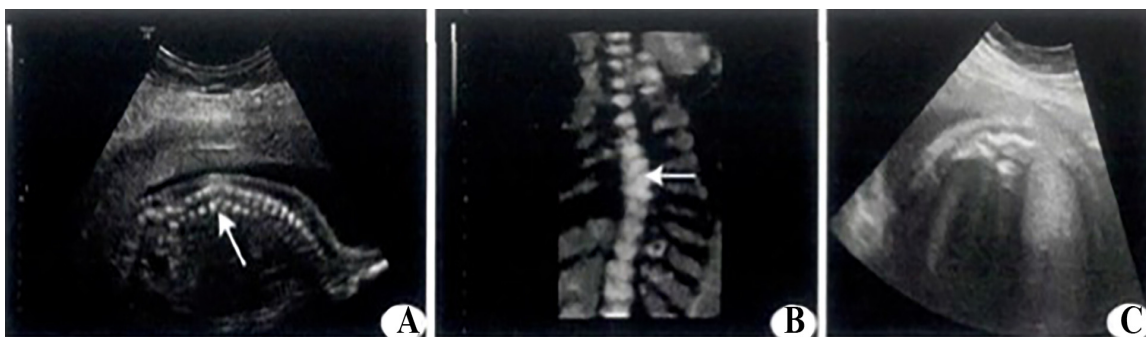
Ultrasonogram of fetus hemivertebra deformity (A: 2D ultrasonic sagittal view arrow of the vertebral column indicated that lesion vertebral body is smaller than those nearby, with partial loss; B: 3D ultrasonic coronal arrow of the vertebral body was in the shape of triangle; C: The cross section vertebral body was smaller than the normal one and the shape was irregular).
